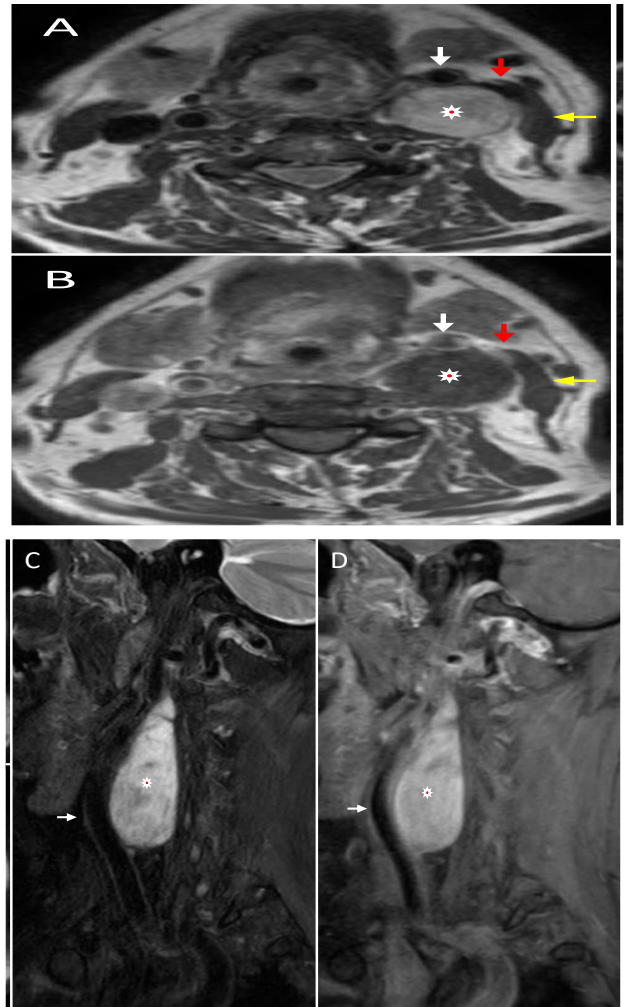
(A-D): MRI neck with contrast: axial T2, axial T1, sagittal STIR shows a well-defined oval-shaped T1 isointense, T2 hyperintense mass lesion (star) centred in the left carotid space posterior to the carotid artery (white arrow) and internal jugular vein (red arrow) and medial to the sternocleidomastoid muscle. The common carotid artery and internal jugular vein are displaced anteriorly by the lesion. Sagittal postcontrast T1: The lesion shows intense contrast enhancement.
